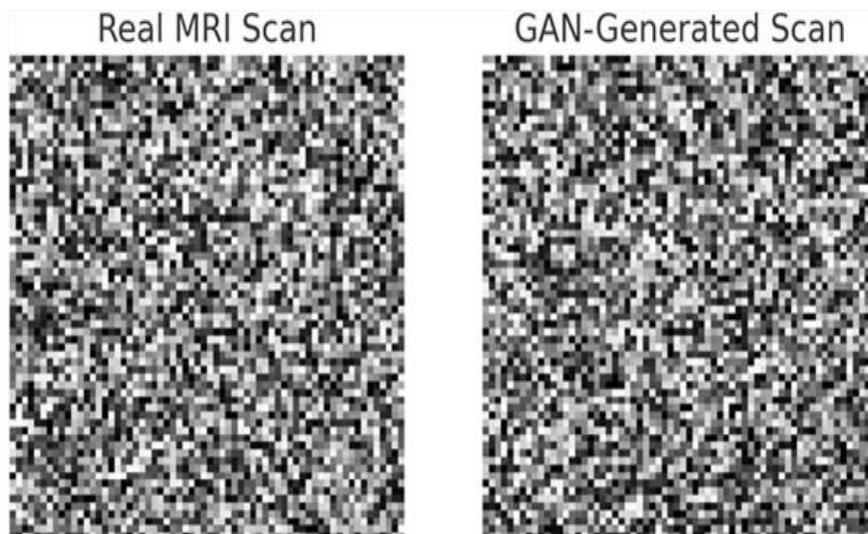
Real MRI and GAN-Generated Scans
